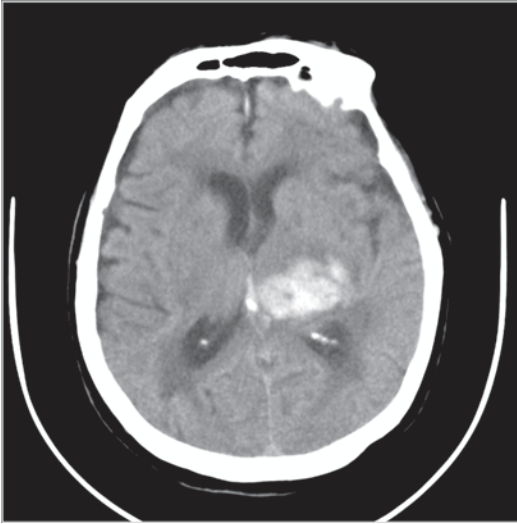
Computed tomography (CT) scan of acute intracerebral hemorrhage in left thalamus due to hypertension. (Courtesy of Blaine Hart, MD)
